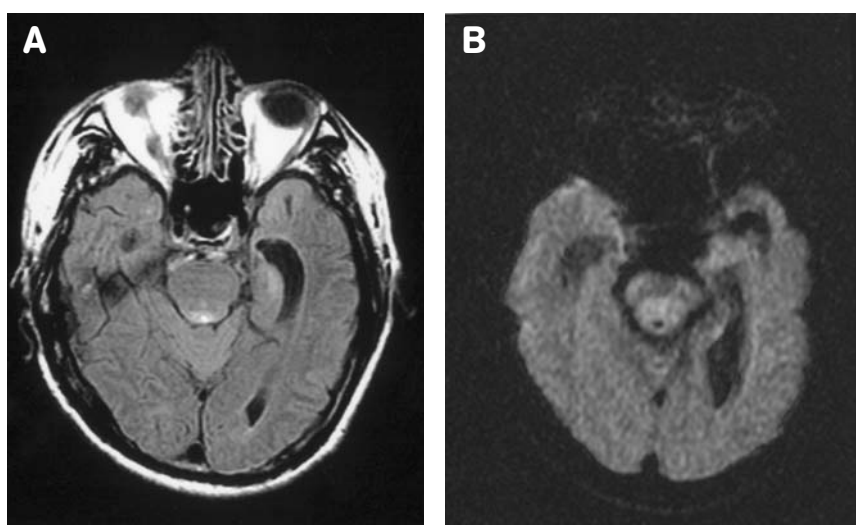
Two months after admission. (A) Axial FLAIR imaging, (B) Diffusion-weighted imaging, both revealed that previous high-intensity lesions over bilateral mesial temporal regions almost completely resolved.
